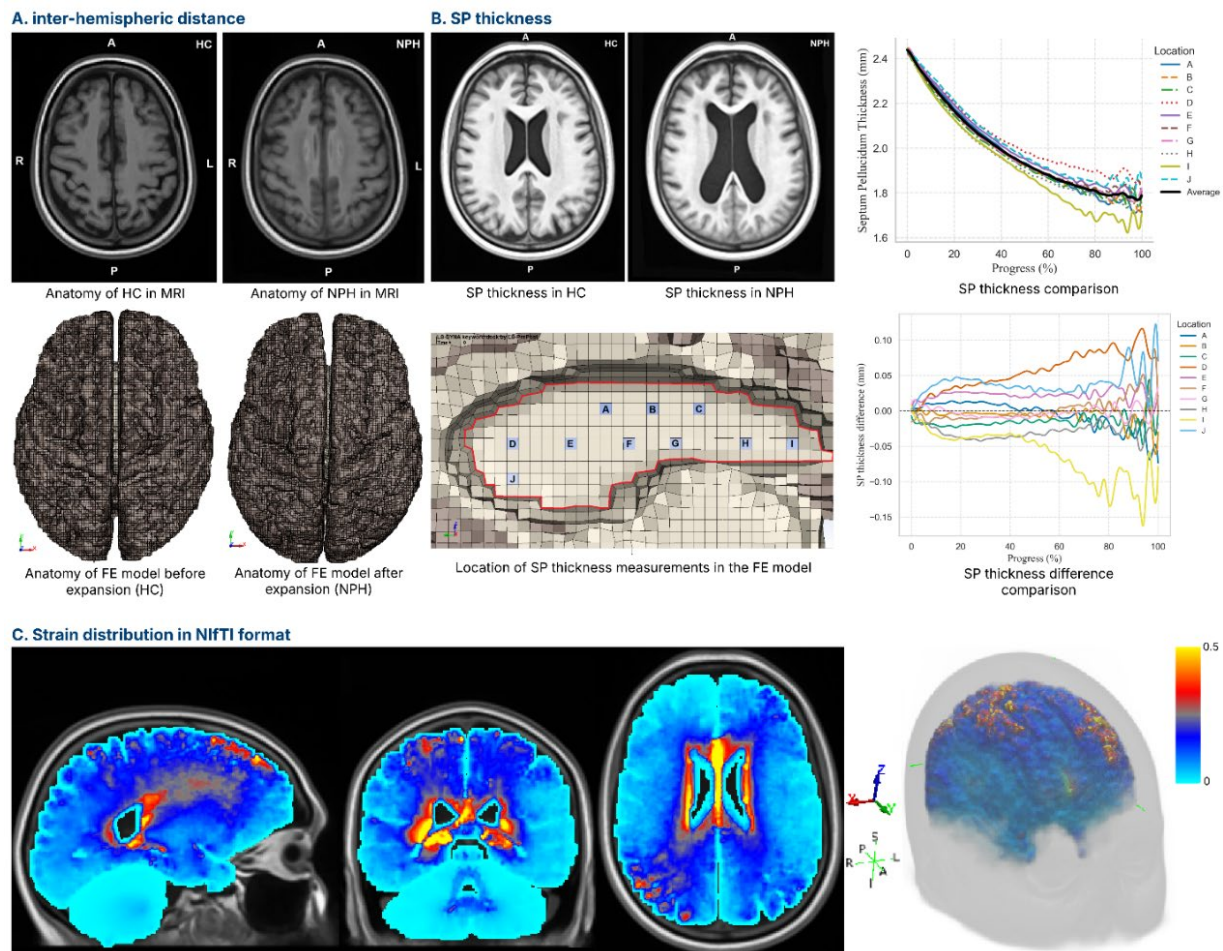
(A) MRI and model predicted decrease in the inter-hemispheric distance. (B) MRI and model predicted reduction in SP thickness, with a greater reduction in posterior regions. (C) Strain distribution in NPH brains.
